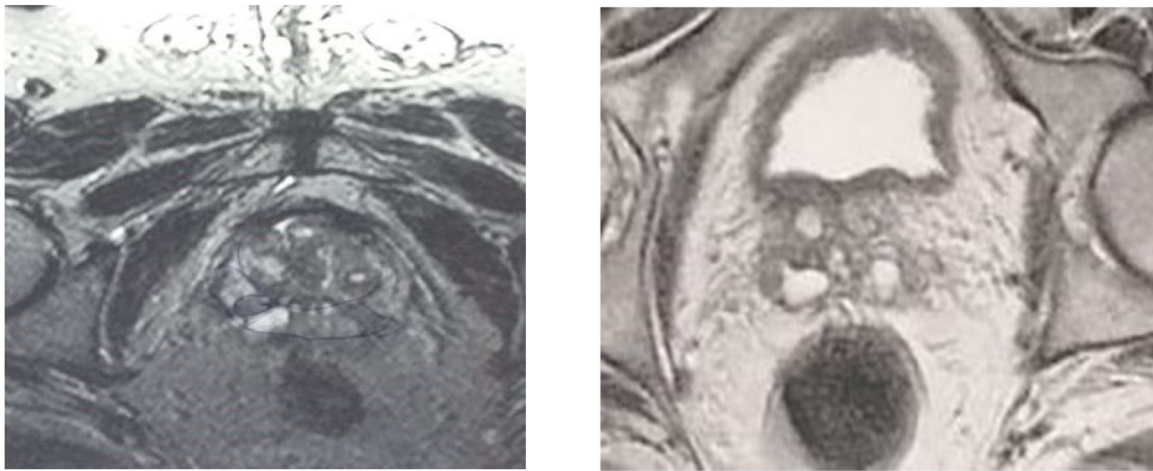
Prostatic MRI showing found a lesion of the right posterolateral area classified as PIRADS 4.
